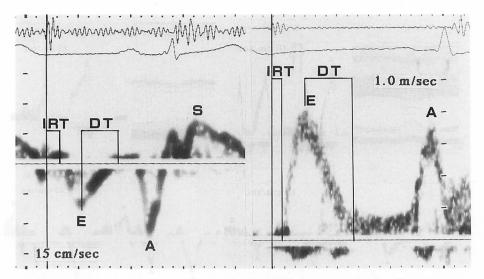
Measurement techniques in intramyocardial pulsed Doppler (left) and transmitral Doppler (right)
